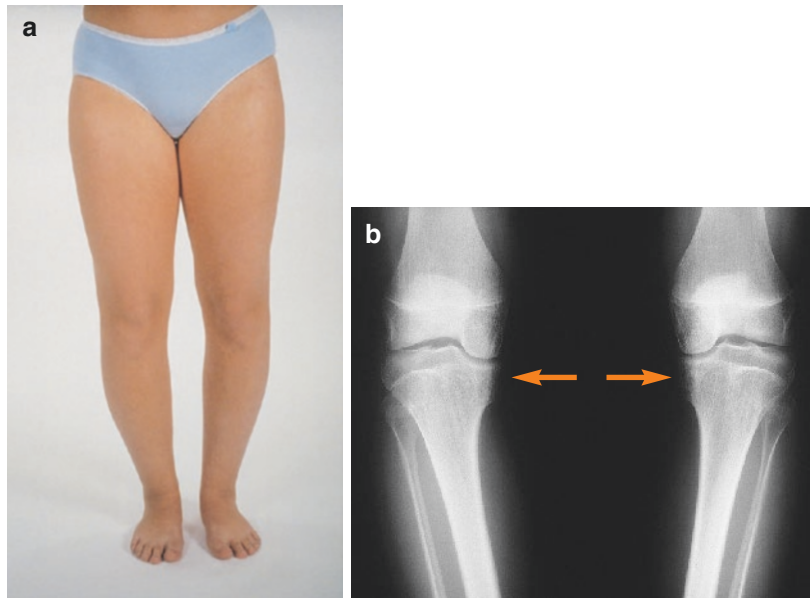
(a) Bilateral Blount disease (adolescent type). This 15-year-old girl developed genua vara within a half year due to a bilateral Blount disease. (b) Anteroposterior X-ray of the knees of the same girl as in 10.6a. On the medial side a bony connection has appeared between the proximal tibial metaphysis and epiphysis (arrow). The lateral part of the proximal tibial growth plate is intact and keeps growing causing a bowleg
